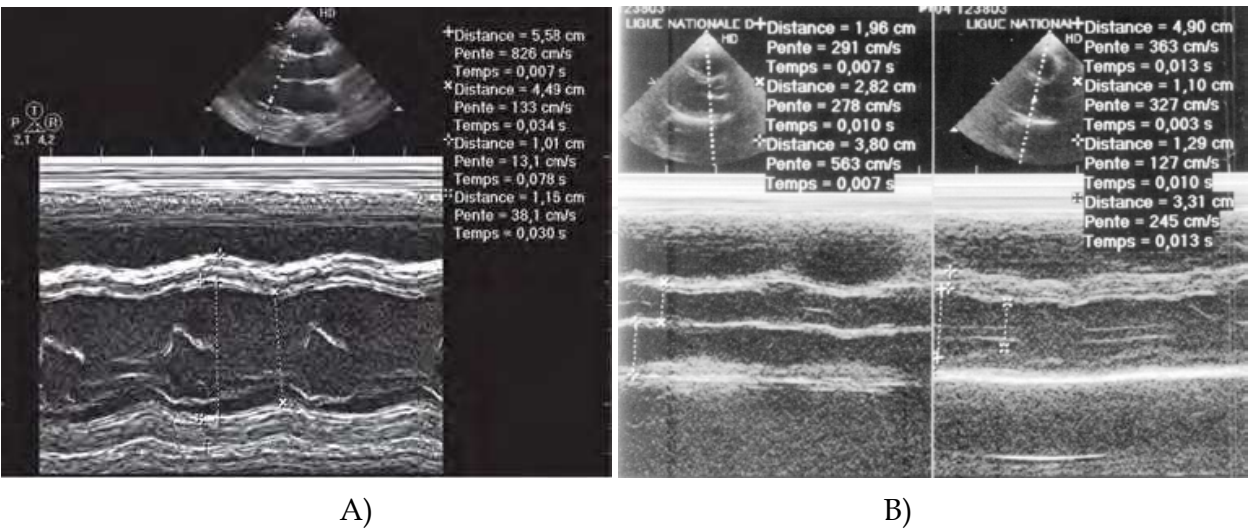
Echocardiographically parasternal long axis depicted improvement of ventricle function following aluminum phosphide poisoning . A) Echocardiogram obtained on the second day after admission depicts global hypokinesis with LVEF of 30% and dilatation of LV. B) Echocardiogram taken eight days after admission showed improvement of ventricle function.
